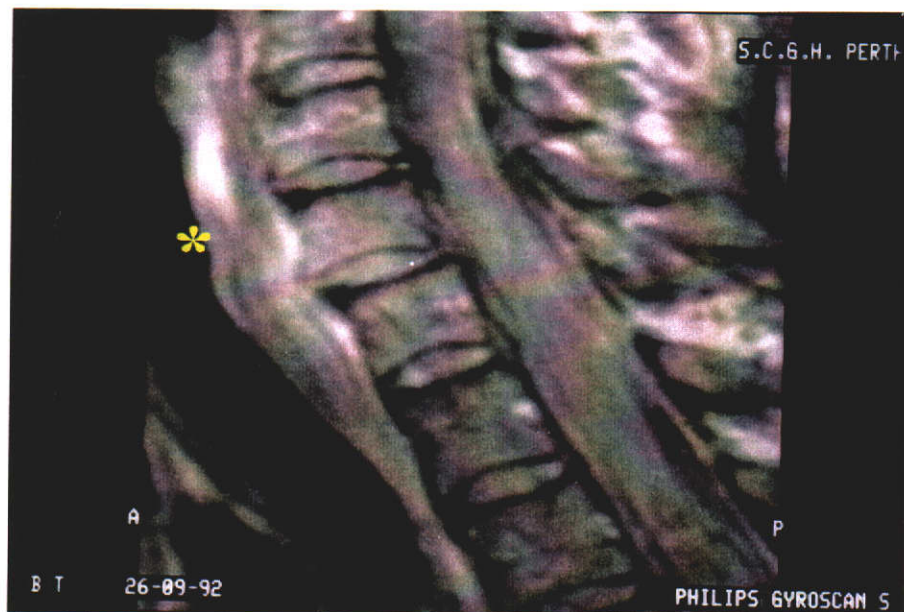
MRI performed after three months post-injury showing resolution of pre-vertebral swelling
